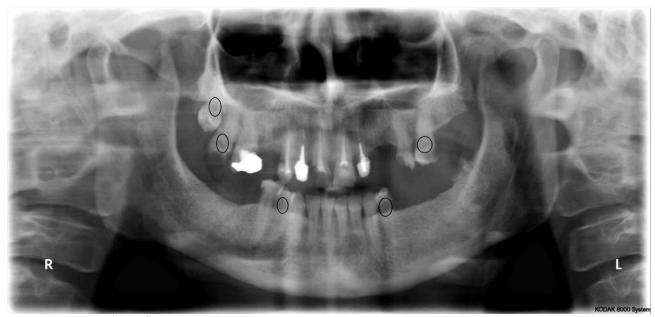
Panoramic radiograph revealed pulp stones in most of the permanent teeth
